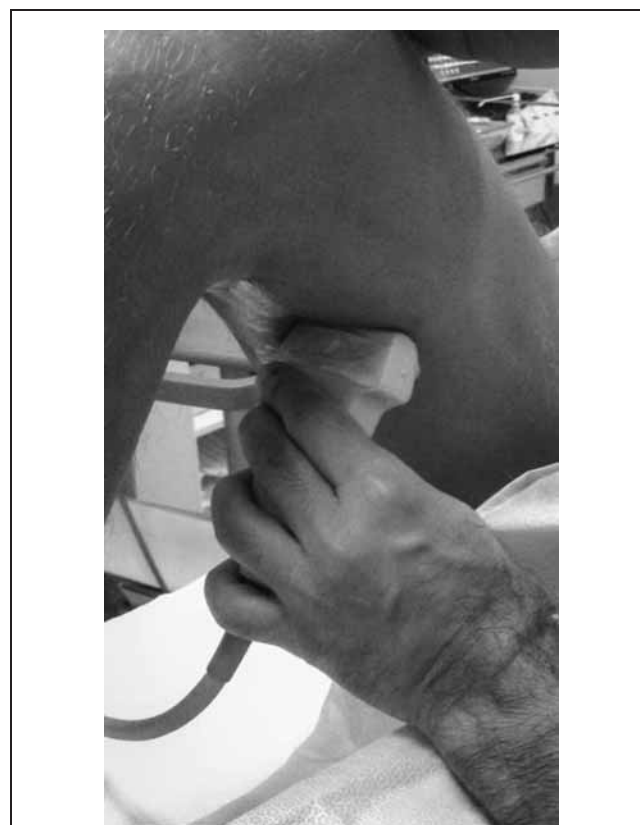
Ultrasonography guided peritendinous administration of anaesthetic
